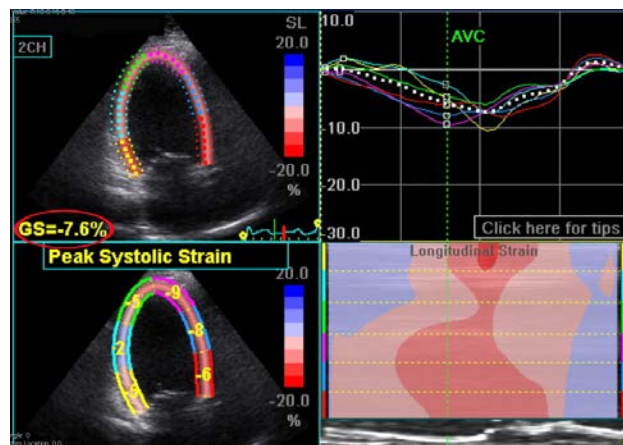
Segmental and global strain results recorded from the apical 4-chamber view. A segmental strain score is automatically applied to each myocardial segment. A global strain score is also applied to each apical view imaged (circled). Note the abnormally low segmental and global strain recordings this heart failure patient in comparison to the scores recorded in the normal control subject shown in Figure 1.19.
